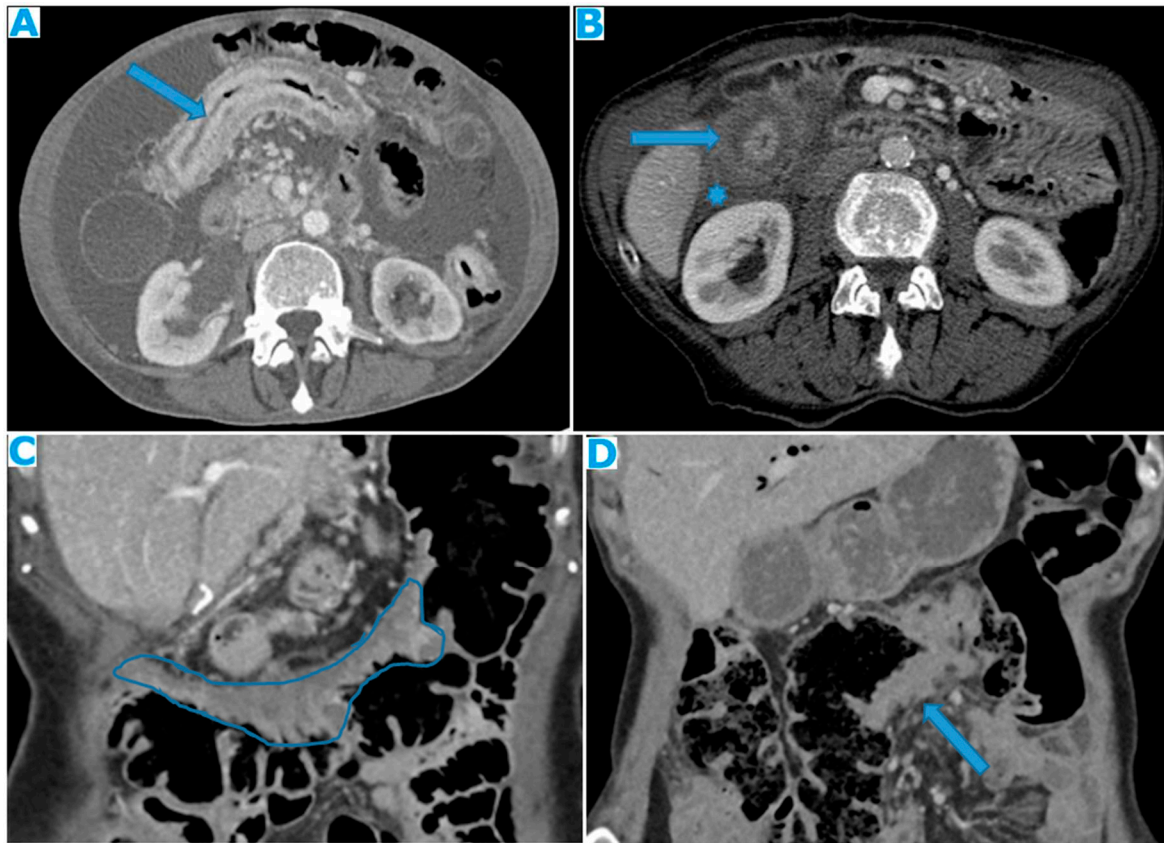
Axial CE-CT (A). PC from breast carcinoma: Deposits within the transverse colon serosa (arrows), causing luminal stenosis. Axial CE-CT (B). PC from breast carcinoma: Layered deposits within the transverse colon serosa (arrow), notice the concentric pattern and the luminal stenosis. Ascites (*). Coronal CE-CT MPR (C-D). C: PC from signet ring cell gastric carcinoma. Diffuse serosal infiltration of the transverse colon. D: PC from breast carcinoma: Segmental parietal thickening of the transverse colon due to nodular deposits within the serosa (arrow). Observe how layered deposits on C blend in with the bowel contour and may be more difficult to detect than nodular deposits on D.
